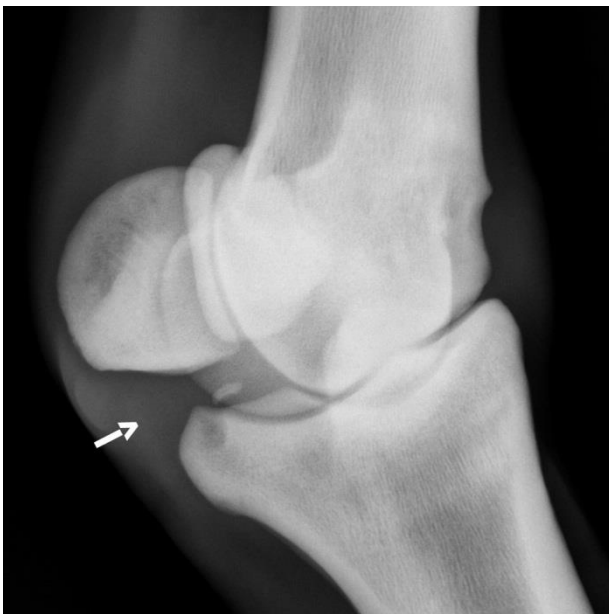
Dorsolateral-palmaromedial oblique radiographic view of metacarpophalangeal joint showing an articular fragmentation of proximal palmar phalanx one (arrow).
